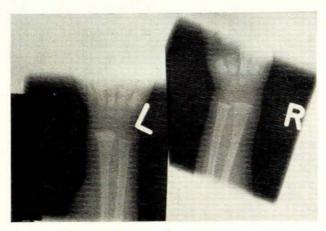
Radiographs of hands after treatment.
